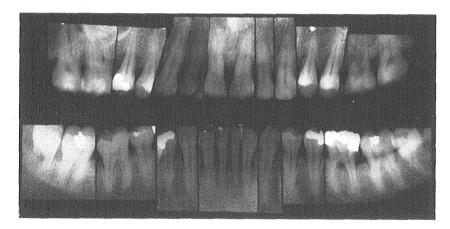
Roentgenograms show that the periodontal problem is worst around the anterior teeth.
